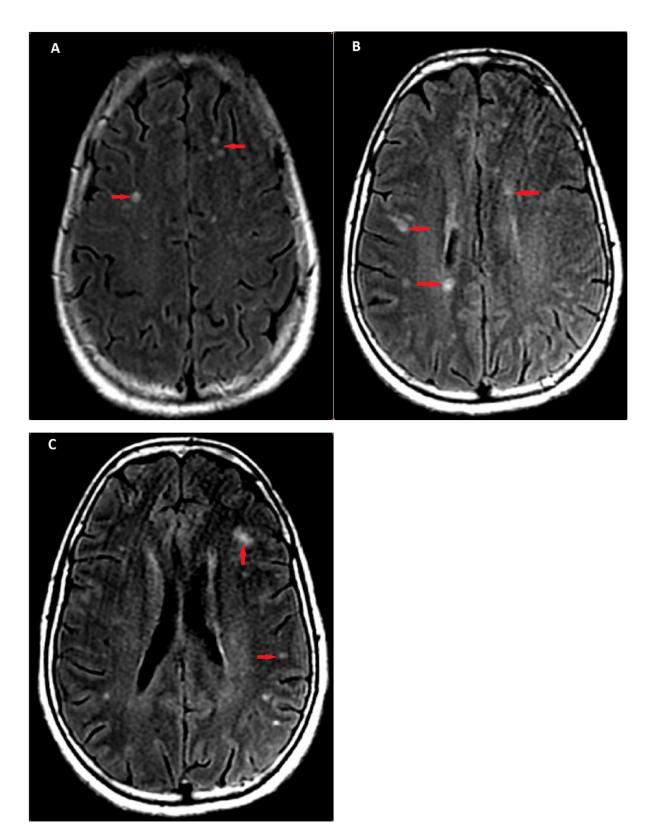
MRI with axial FLAIR sequences (A-C): shows multiple lesions of increased signal (red arrow), mostly punctiform and rounded in shape, involving the deep white matter, the white matter-gray matter junction, subcortical and periventricular regions, at frontoparietal level bilaterally. All these lesions are related to micro-infarcts caused by infectious vasculitis in the context of rickettsiosis.
